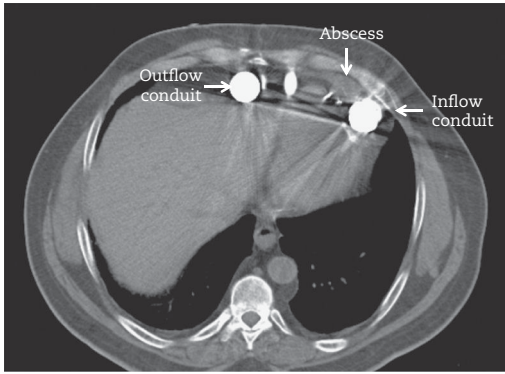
CT scan demonstrating LVAD infection with abscess formation.
